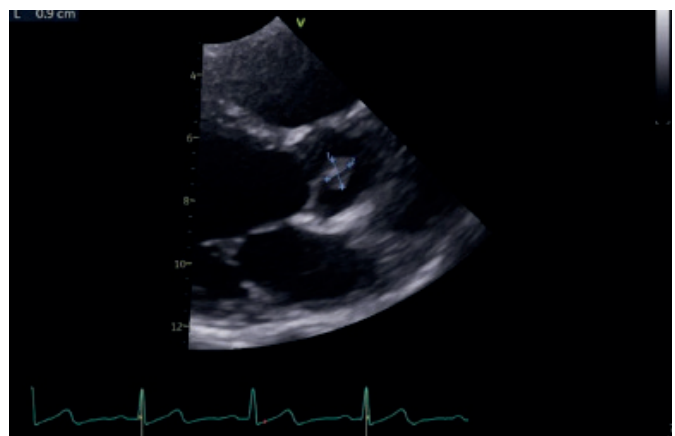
TTE Parasternal long-axis view demonstrating a mass attached to the aortic valve, measuring 9mm x 9mm.
